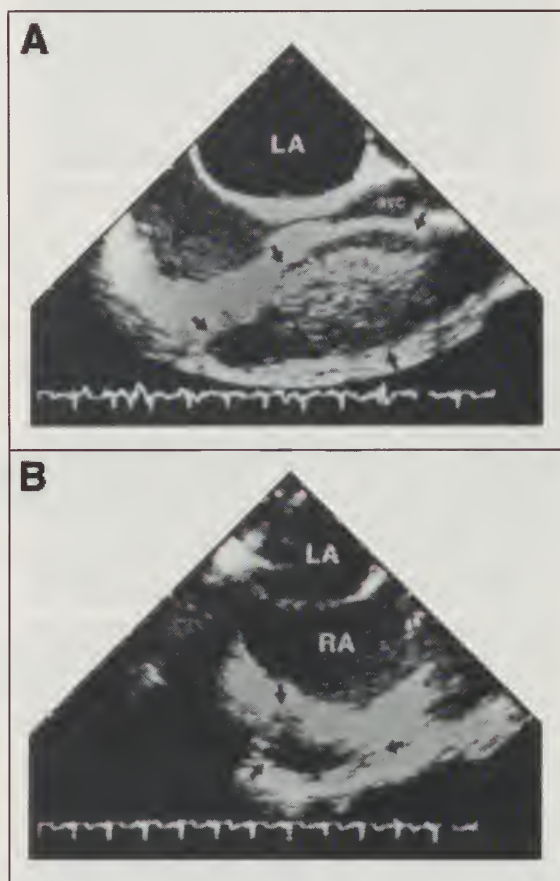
Transesophageal echocardiographic images demonstrating the presence of a well defined echolucent (demarcated by arrows) mass along the anterolateral border of the right atrium in the (A) longitudinal and (B) transverse plane. LA = left atria, RA = right atria, SVC = superior vena cava, and TV = tricuspid valve.
